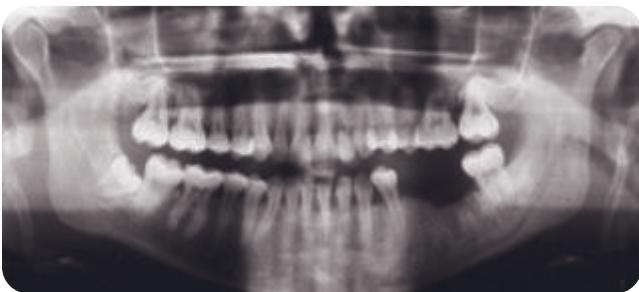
Pretreatment panoramic radiograph suggesting left condylar changes, shortened condyle-ramus height left side, tooth loss lower left, interproximal bone loss upper left. Note bone right side appears within more normal limits.
